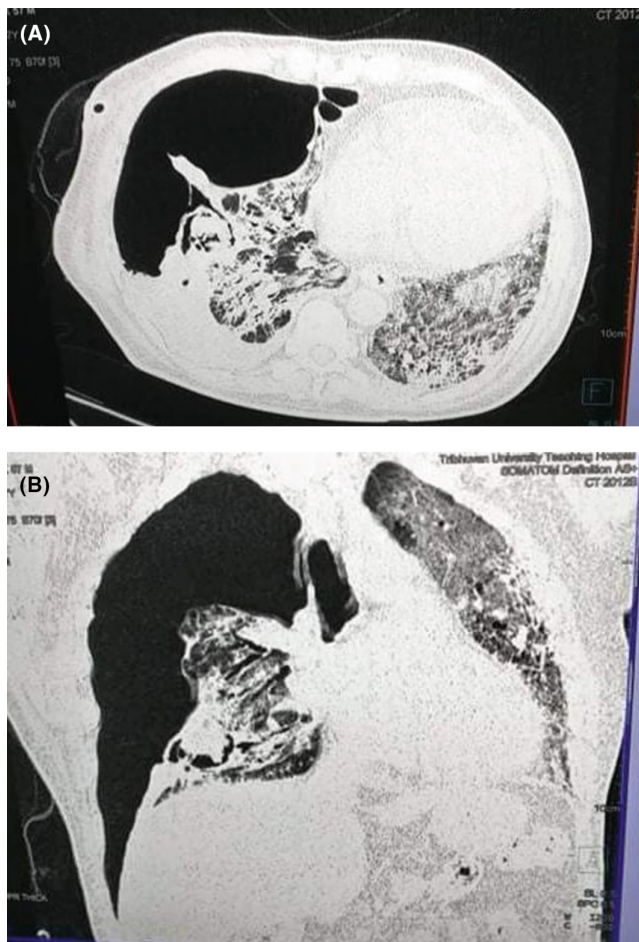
(A,B) HRCT scans showing right-sided hydropneumothorax with an intermediate walled cavity in the right lower lobe with BPF and multifocal consolidation with ground glass in bilateral lung fields with fibro bronchiectatic changes and crazy pavement patterns.
